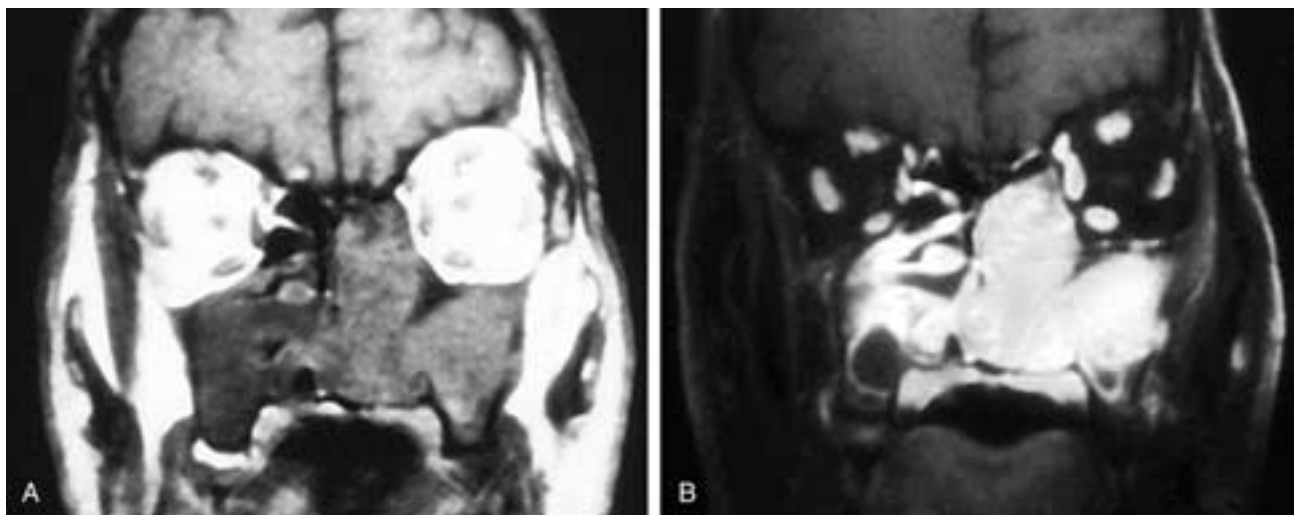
Coronal T1-weighted MR scans without contrast (A) and with contrast (B) show a mass in A of intermediate signal intensity that has destroyed some of the left antral walls and fills the left nasal fossa. Lower signal intensity material (secretions) fills the right antrum and nasal fossa. This appearance accurately reflected the findings at surgery. In B, the tumor enhances, the inflamed mucosa enhances, and some normal right ethmoid mucosa enhances. This presents a falsely large impression of the tumor size. This patient had a squamous cell carcinoma.
